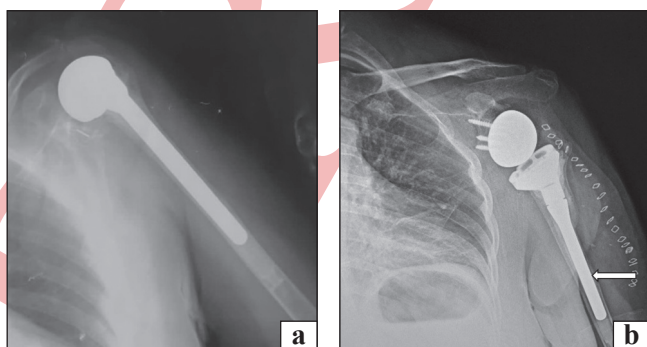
A 58-year-old male patient presented with aseptic loosening of shoulder hemiarthroplasty: a) preoperative plain radiograph of the hemiarthroplasty; b) postoperative radiographs of reverse total shoulder arthroplasty (arrow indicates lateral cortex blowout during cement extraction)
